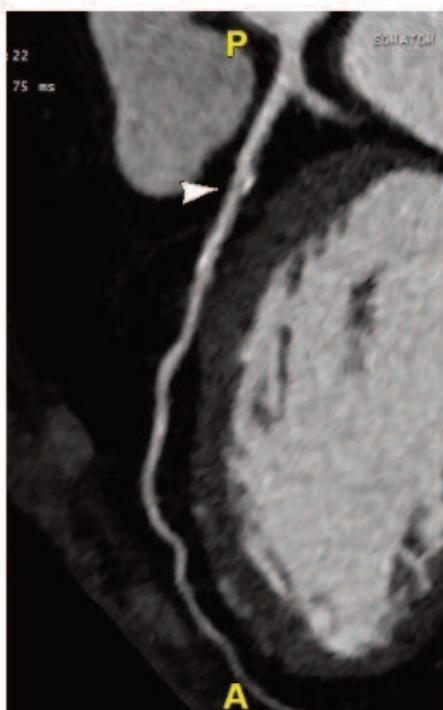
CCTA of a 58-year old female patient demonstrates mild stenosis of the LAD (left, arrowhead). However, FFR-CT (above) showed this to be a functionally significant obstruction (FFR < 0.8). The patient subsequently underwent PCI.
